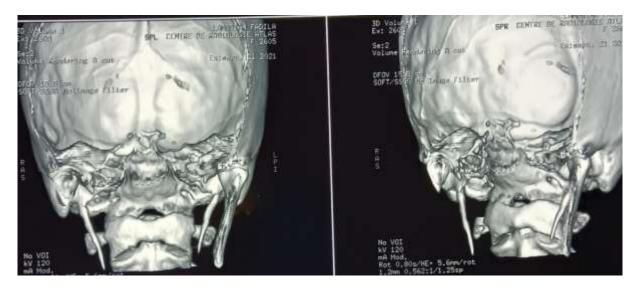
cervico-facial CT scan – axial cuts – showing the ossification of the stylohyoid ligament
